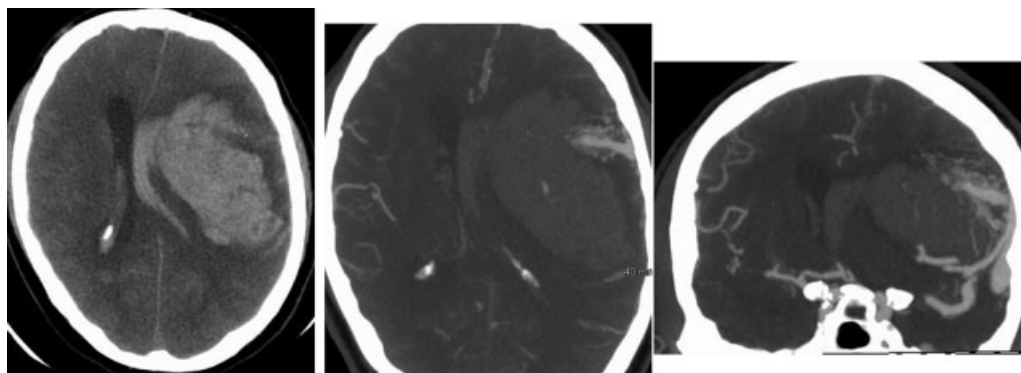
A 43-year-old woman with poorly controlled diabetes and hypertension who presented with an intracerebral hemorrhage. A dural arteriovenous fistula is demonstrated on computed tomography angiography.
